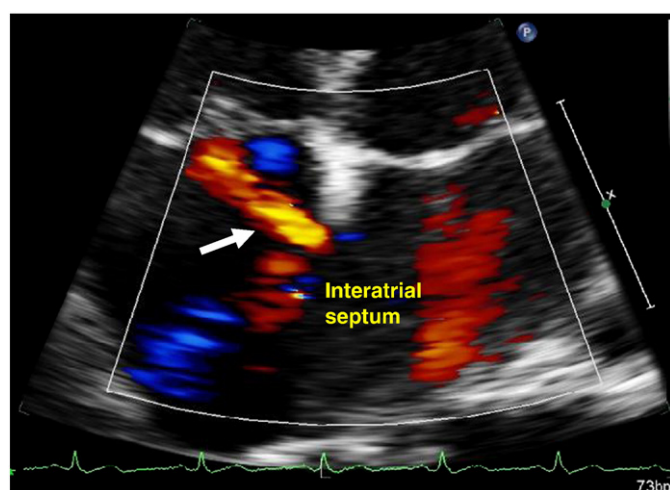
An example of a patient with 2-dimensional color Doppler flow (white arrow) at interatrial septum which is suspicious of patent foramen ovale.
